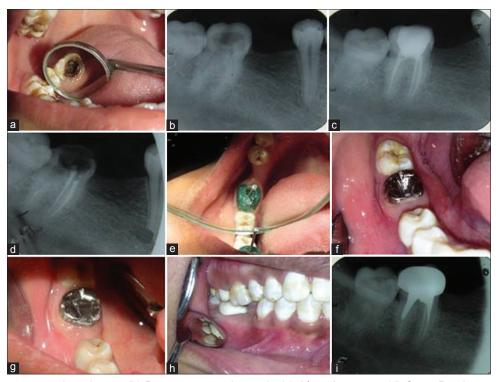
(a) Preoperative clinical view. (b) Preoperative radiograph. (c) After obturation. (d) Gutta-Percha removed from distal canal. (e) Primary (lock) post and core was pattern construction. (f) Primary (lock) post and core was cemented. (g) Secondary (key) post and core was cemented. (h) Porcelain fused metal ceramic crown was cemented (buccal view). (i) Radiograph after the preformed metal crown cementation
